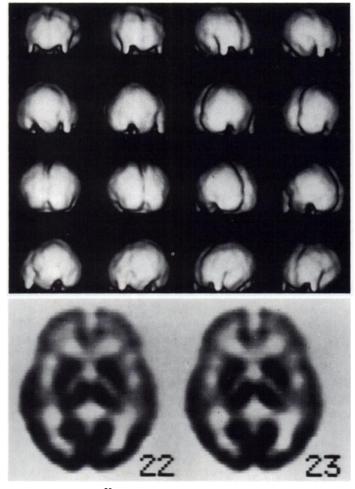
Normal <sup>99m</sup>Tc-HMPAO brain imaging findings in a 25-yr-old woman. Surface three-dimensional display of the brain (upper) and fanbeam SPECT (transaxial slices) of the brain (lower) reveal homogeneous rCBF in the gray matter of basal ganglia/thalamus and cerebral cortex without focal hypoactivity or visible asymmetry.
